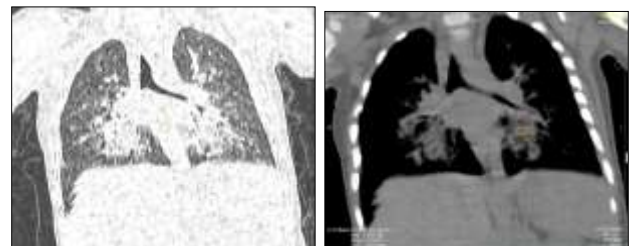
HRCT AND SOFT TISSUE WINDOW: performed in 16-row multi-slice CT scanner at 90 KV: Reveals perihilar areas of consolidation with air bronchograms. Areas of low attenuation corresponding to fat (- 51 HU average attenuation) seen within these consolidations.
